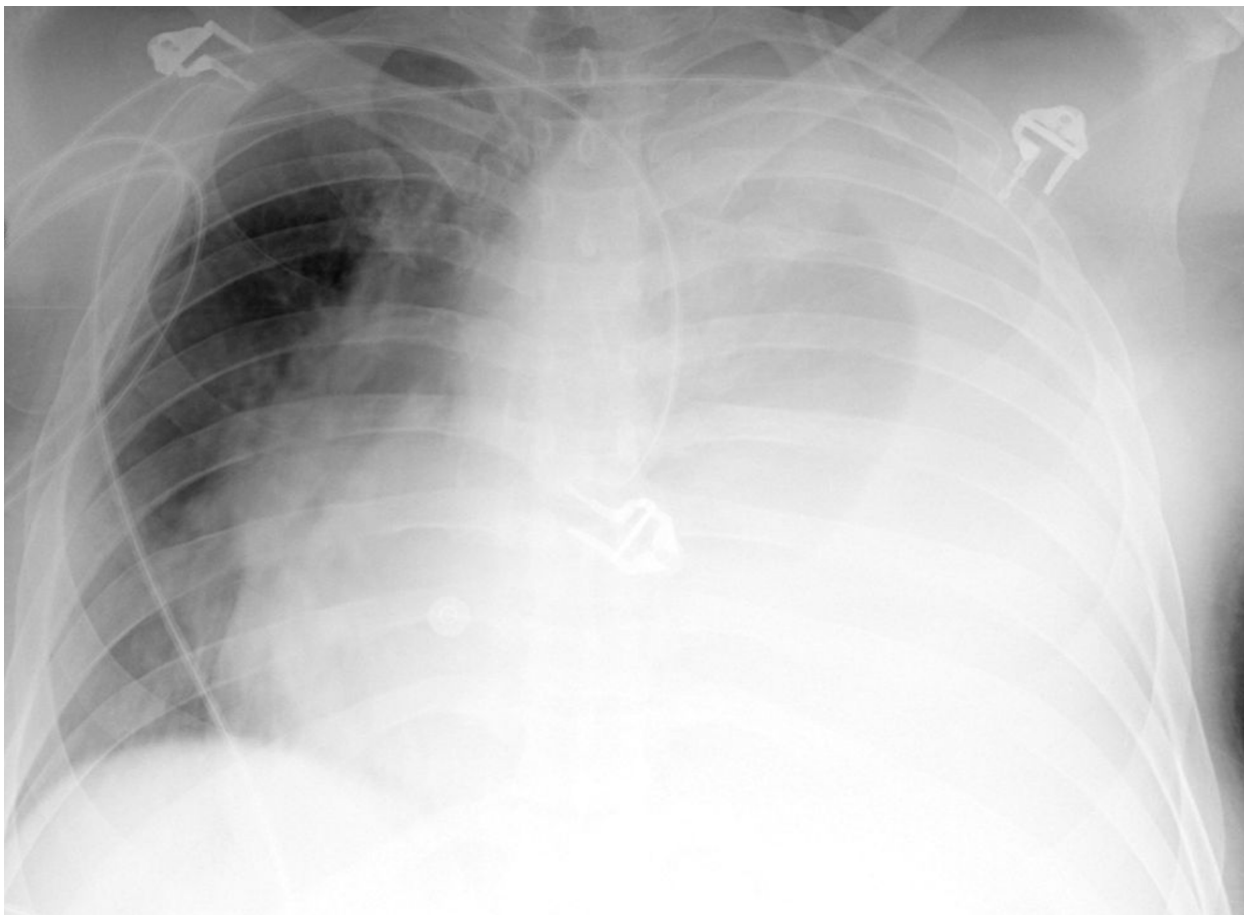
Chest x-ray on admission showing massive left pleural effusion.
